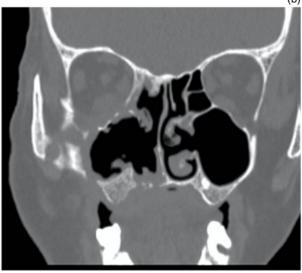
(a) Three-dimensional and (b) coronal two-dimensional computed tomography images showing destruction of right infra-orbital floor, ipsilateral alveolus and zygomatic process.
